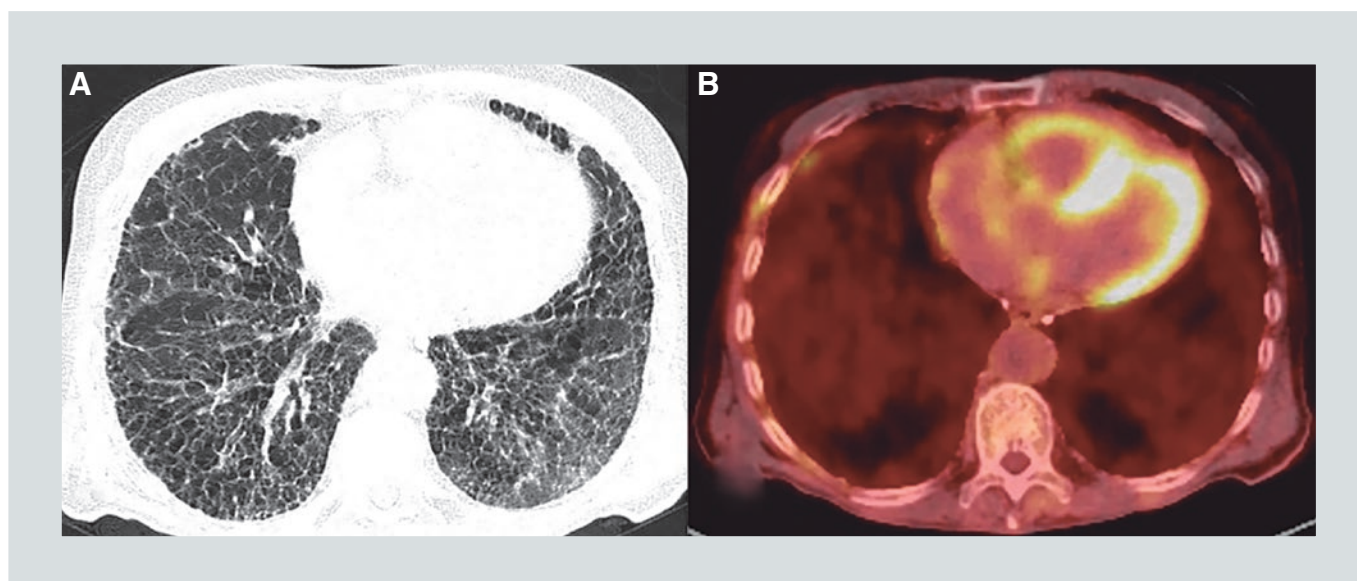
(A) HRCT image of a fibrotic pattern with diffuse honeycomb in the lower lobes. (B) Corresponding FDG-PET image with no FDG uptake within the areas of lung fibrosis. Physiologic FDG uptake is observed in the heart.
